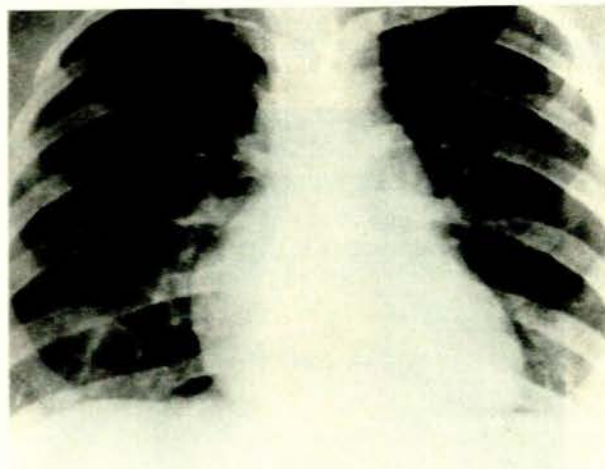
X-ray of the chest showing a solitary lung abscess in the right lower lobe.
